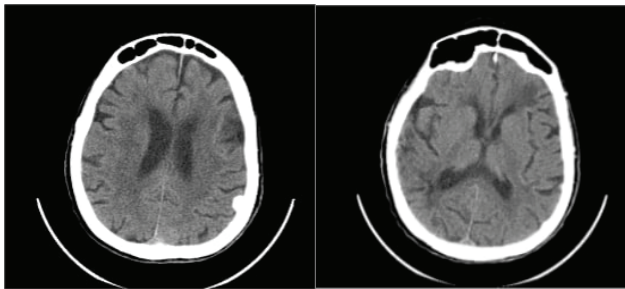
(a), (b): A native brain computed tomography (CT) scan suggests an appearance suggestive of supratentorial sequelae and a left parietal meningioma.
